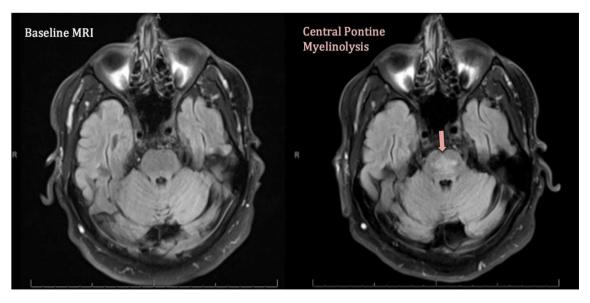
Magnetic resonance imaging (MRI) with evidence of central pontine myelinolysis. Baseline is on hospital day 3. Central pontine myelinolysis is seen on day 25 after admission
